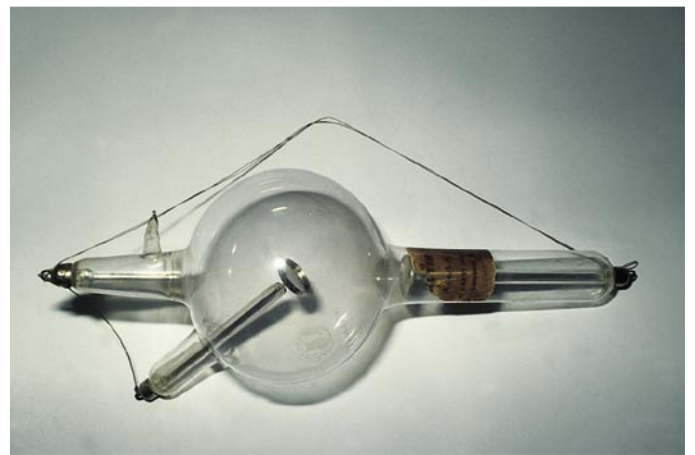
One of the first tubes used at the turn of the century to produce X-rays.
